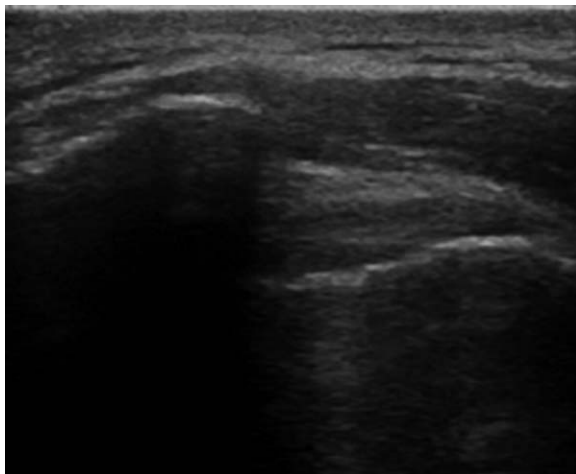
Ultrasound image for AHD measurement.
